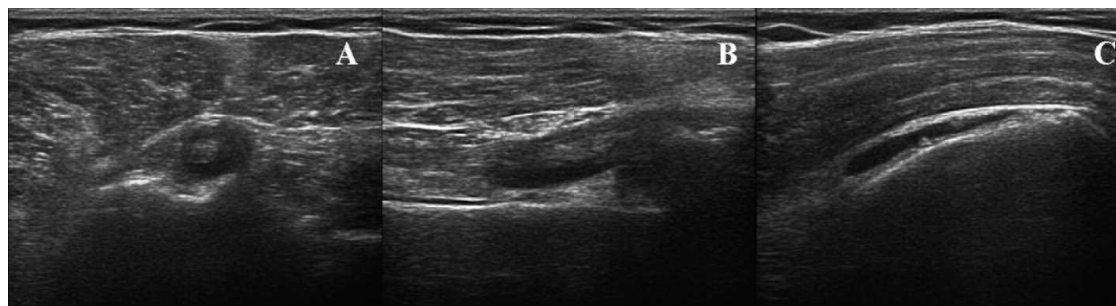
(A) Anterior transverse and (B) longitudinal LHB tendon ultrasound scans showing LHB tenosynovitis, and (C) SB scan showing SB effusion. LHB: long head biceps; SB: subdeltoid bursitis.
